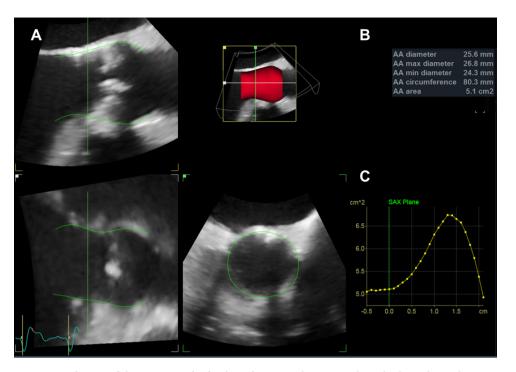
Evaluation of the aortic annulus by three-dimensional transoesophageal echocardiography using automated software (4D Automated Aortic Valve Quantification (4D Auto AVQ); EchoPAC, version 201, GE-Vingmed). First, a multiplanar reconstruction of the aortic valve is constructed in mid-systole by aligning the two long-axis orthogonal planes through the aortic valve and moving the transverse plane toward the hinge points of the aortic valve leaflet insertions. Automatic delineation of the left ventricular outflow tract and aortic root is then performed by the 4D Auto AVQ program and, if needed, manual adjustments can be made (*panel A*). After approval of the contouring of the aortic annulus (AA) and aortic root, the automatic software computes the annular dimensions: average diameter (calculated based on the perimeter), maximum and minimum diameters, circumference (perimeter) and area (*panel B*). The software generates a graph representing the cross-sectional area along the aortic root and left ventricular outflow tract (*panel C*).
